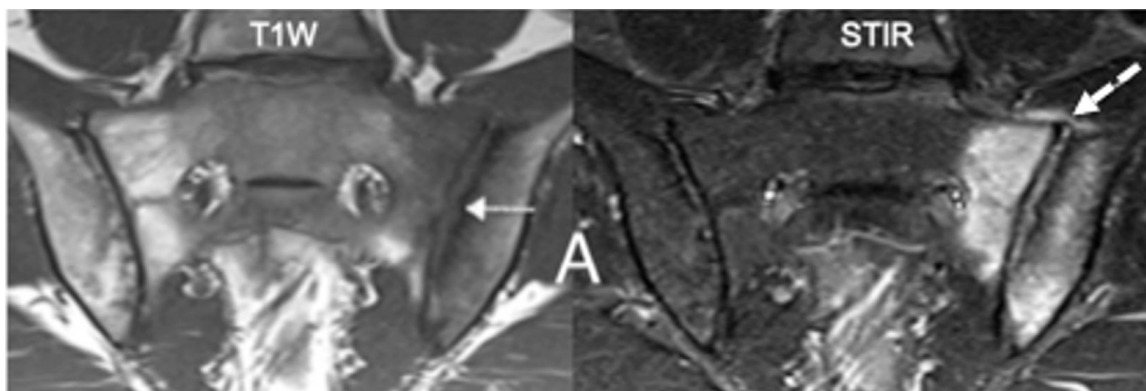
MRI scans of a patient with axSpA. Extensive bone marrow oedema in the left iliac and sacral subchondral bone marrow is depicted as bright signal on the STIR MRI scan meeting the ASAS definition of a positive MRI. There is loss of the bone marrow fat signal in the corresponding location on the T1-weighted (T1W) scan and erosion of the entire vertical height of the left iliac cortical bone with loss of adjacent marrow matrix leading to an appearance of widening of the joint space (arrow). This meets the ASAS definition for erosion. The dashed arrow points to bright signal in the anterosuperior joint capsule on the STIR scan meeting the ASAS definition of capsulitis. Extracted from Maksymowych WP, Lambert RG, Østergaard M, et al. Ann Rheum Dis. 2019 Nov;78(11):1550-1558.
